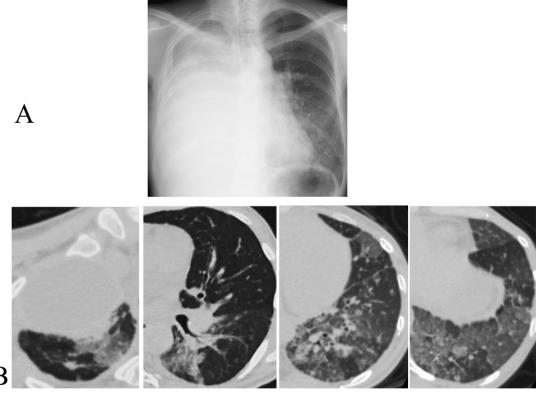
Crizotinib-induced interstitial lung disease (ILD), fourty-seven days after initiating crizotinib. (A) Chest radiograph revealed ground-glass opacity in the left lung, although right pleural effusion decreased. (B) Her CT scan showed diffuse ground-glass opacities in both lungs despite the improvement of lymphangitis carcinomatosa.
